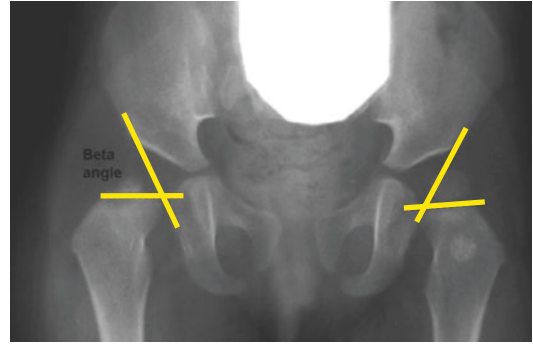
Beta angle measured on AP radiograph
